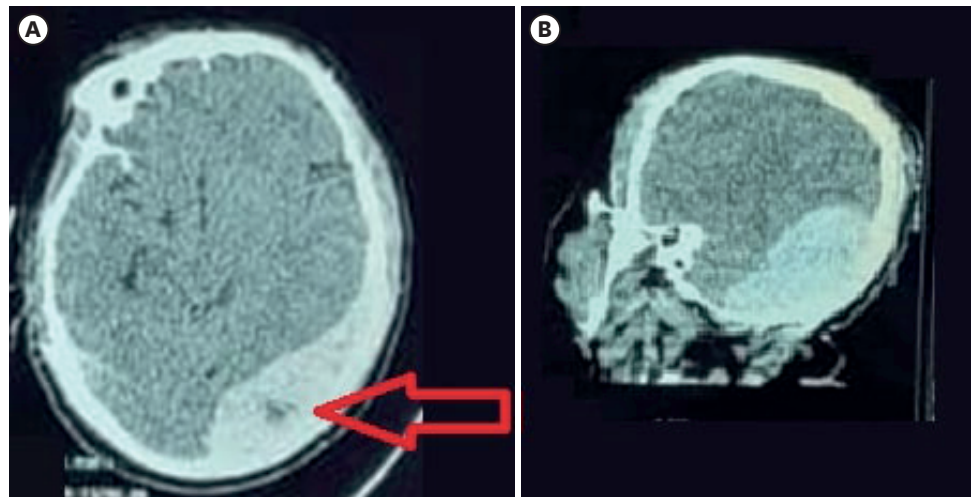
Initial CT scan (case 4). Axial (A) and Sagittal (B) sections of a brain computed tomography scan showing a left Supratentorial infratentorial Epidural hematoma. The red arrow on (A) shows the “swirl sign”.
